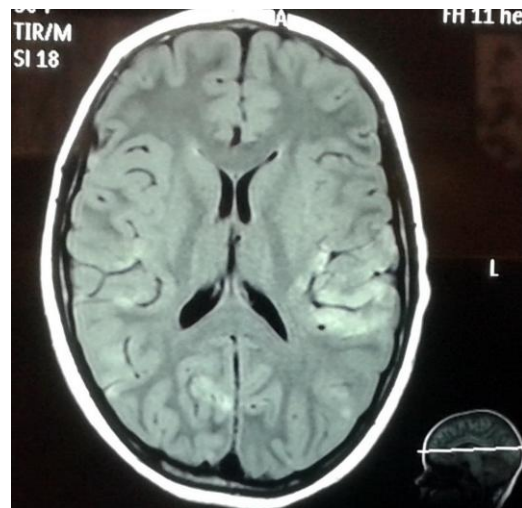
Axial MRI showed multiple inflammatory and ischemic changes in brain tissue.
